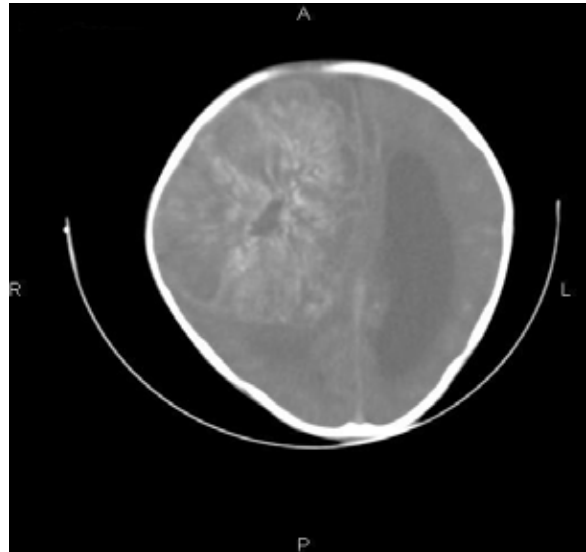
CT scan of a 6-year-old boy showing a well-circumscribed huge right fronto-parietal contrast-enhancing astrocytoma. Note the effacement of the right ventricle, mild oedema, midline shift, and left lateral ventriculomegaly.
